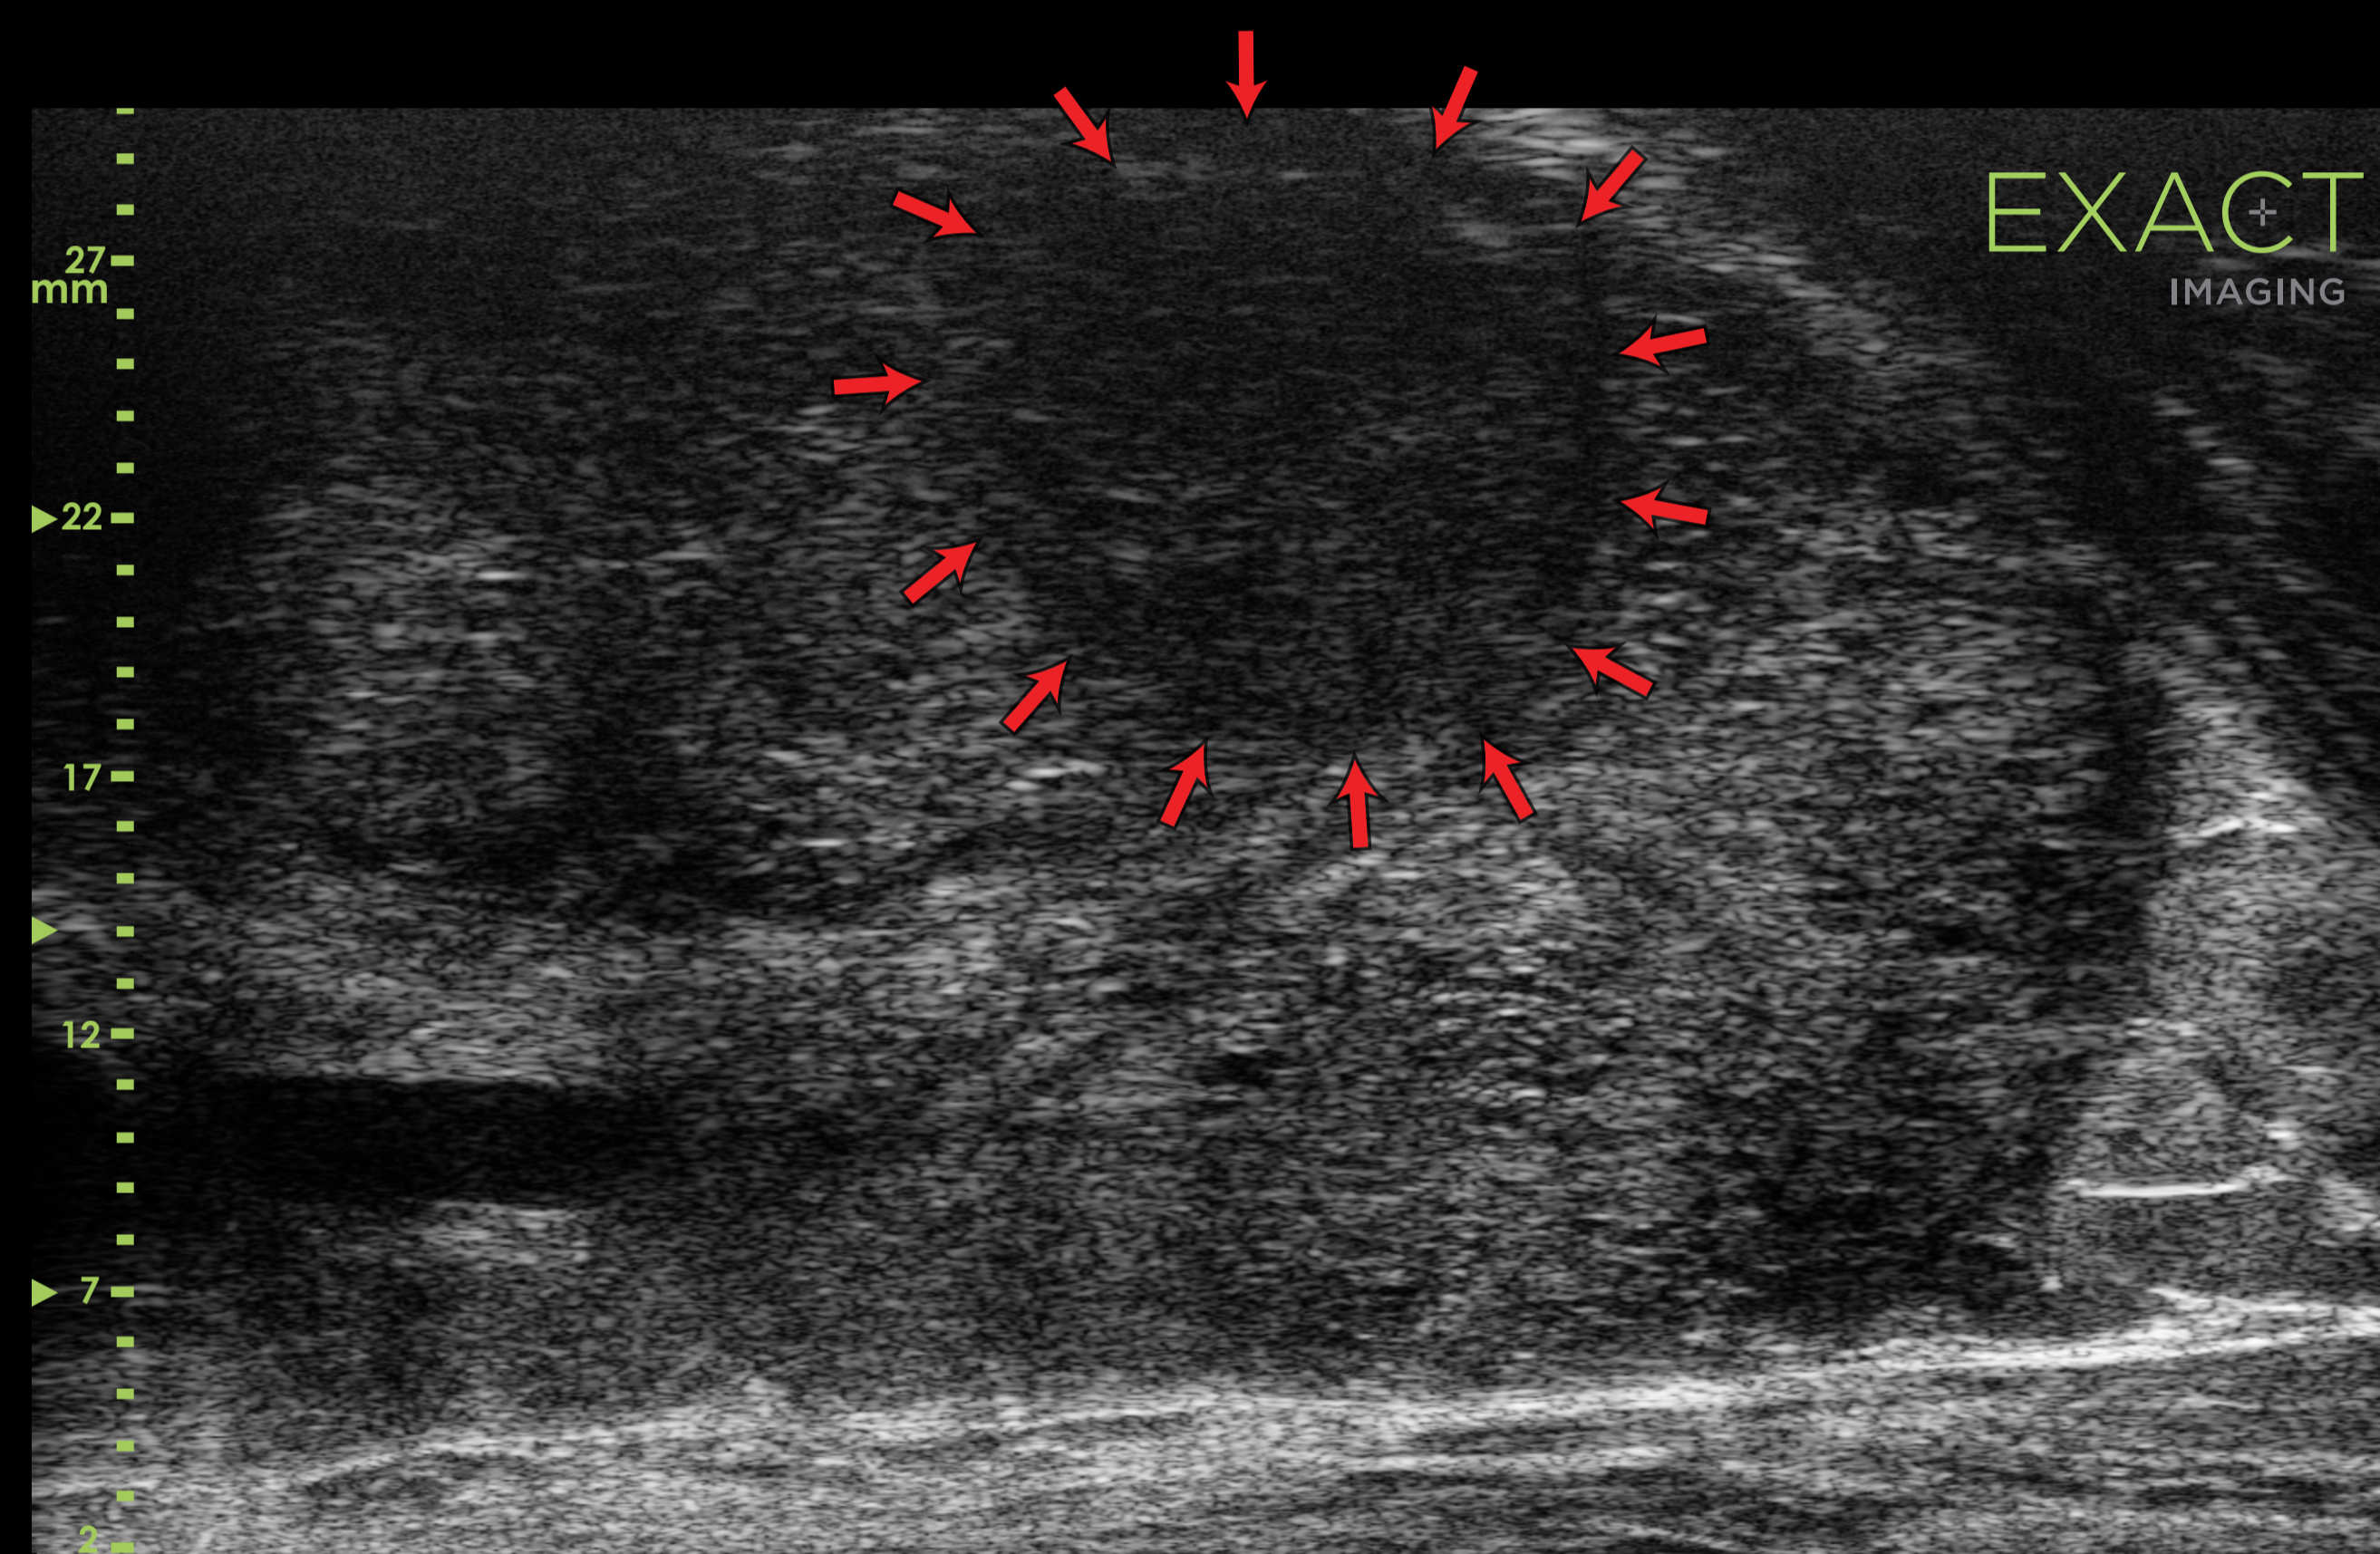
Micro-ultrasound image showing large anterior GG 4 lesion also visualized on mpMRI. This patient had a negative biopsy in 2016, followed by a negative MRI in 2017. A repeat MRI in 2018 showed a lesion in the left anterior zone. Micro-ultrasound biopsy targeted this anterior lesion, which given a GG 4 by pathology. Radical prostatectomy confirmed the location of the lesion but downgraded it to GG 3.
